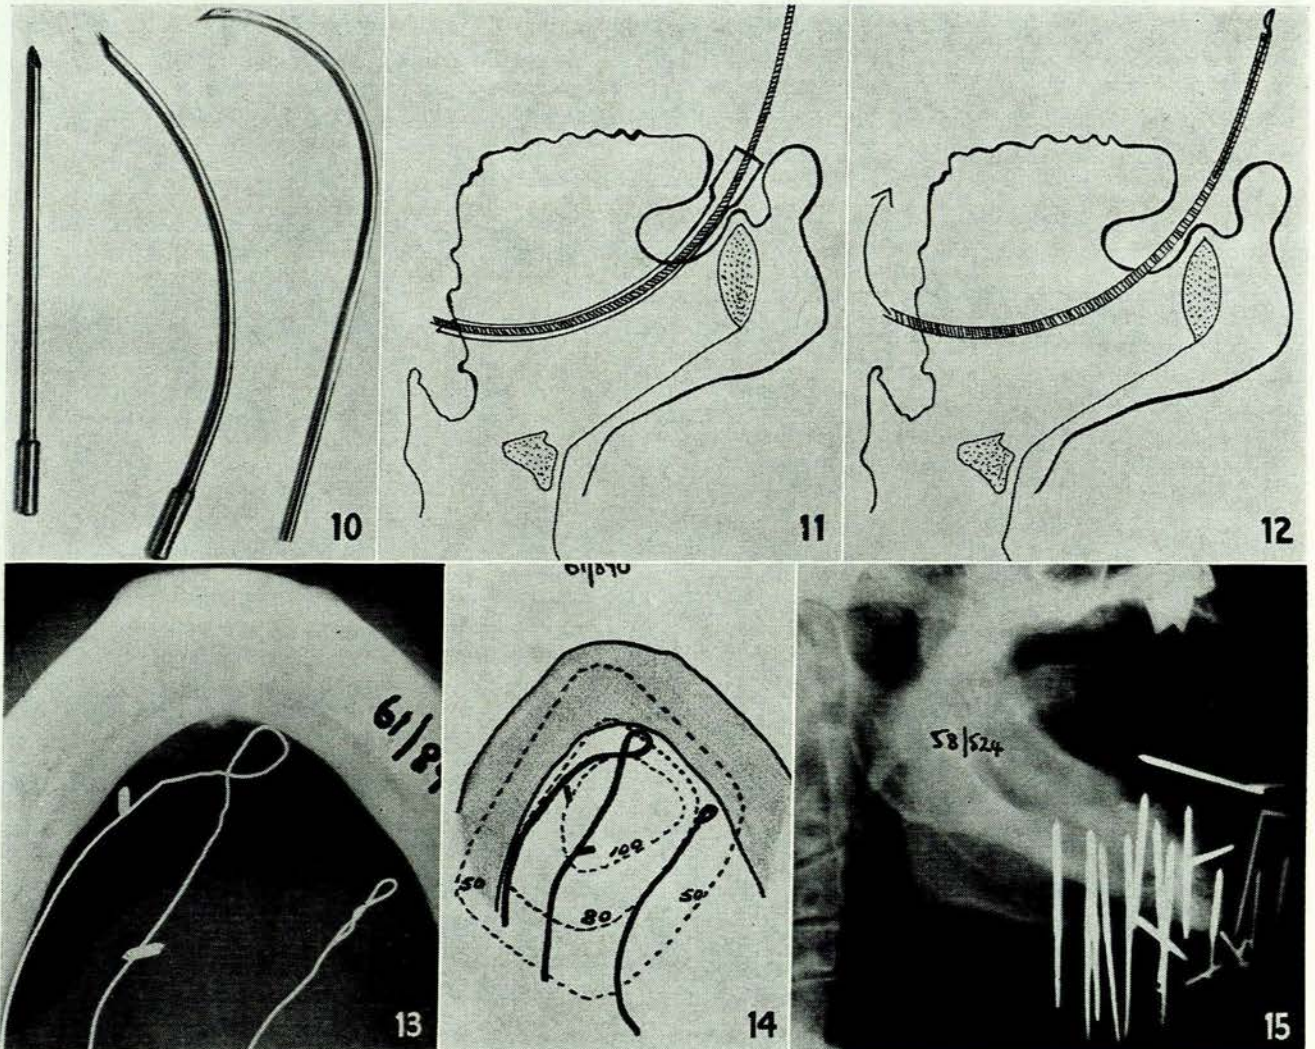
Tubes for the implanting of ^{182}Ta wire in the treatment of carcinoma of floor of mouth (see text). Figs. 11 and 12. Implantation of ^{182}Ta wire in the treatment of carcinoma of floor of mouth (see text). Fig. 13. Carcinoma of floor of mouth. Case 9. Tantalum wires *in situ*. Fig. 14. Carcinoma of floor of mouth. Case 9. Calculated planar isodose at 0.5 cm. Fig. 15. Carcinoma of lower alveolus. Case 1. X-ray of radium implant.
